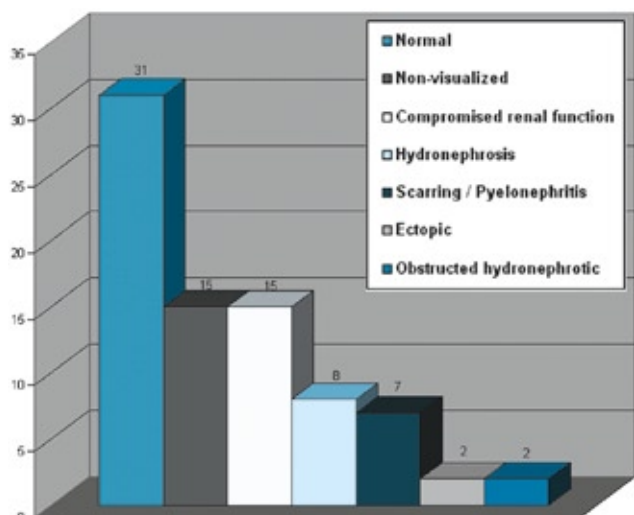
Profile of scintigraphic findings in individual renal units in patients with high ARM.
